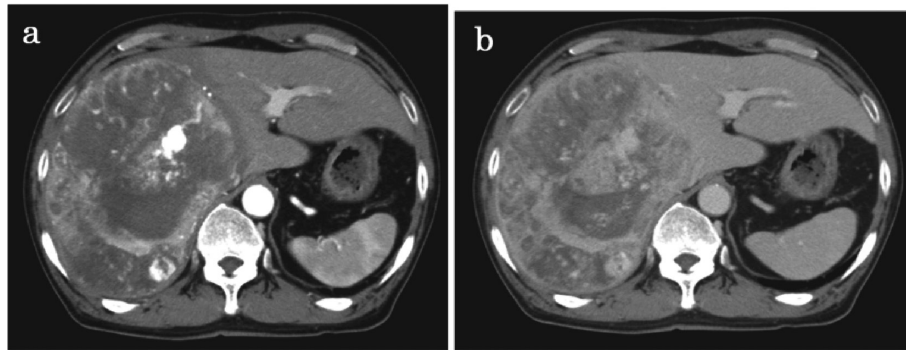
Enhanced computed tomography showing an 18×15-cm tumor in the right lobe of the liver that is well-enhanced in the arterial phase (a) and fast wash-out in the equilibrium phase (b).
